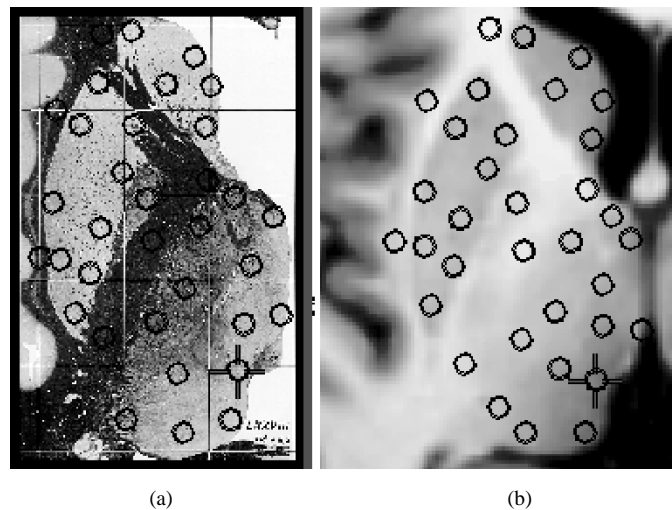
Example of corresponding tag points between (a) the atlas and (b) the MRI model.
